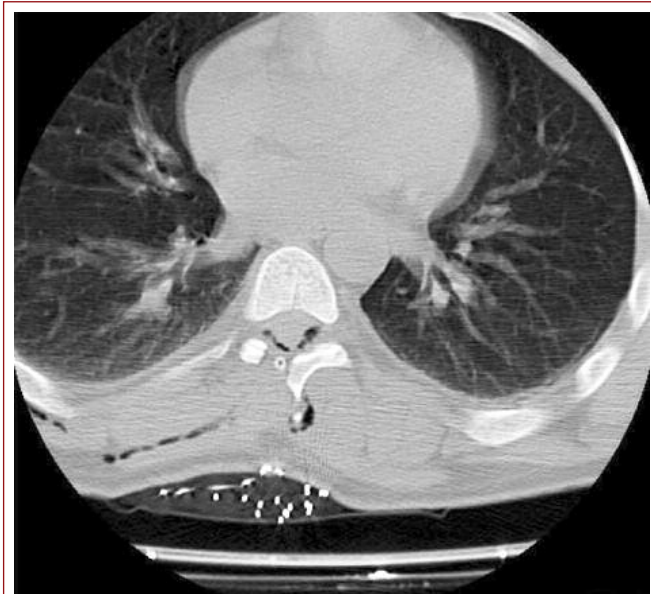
The entry site of the knife in the cord after right T7 hemi-laminectomy in a thoracic vertebral CT.
